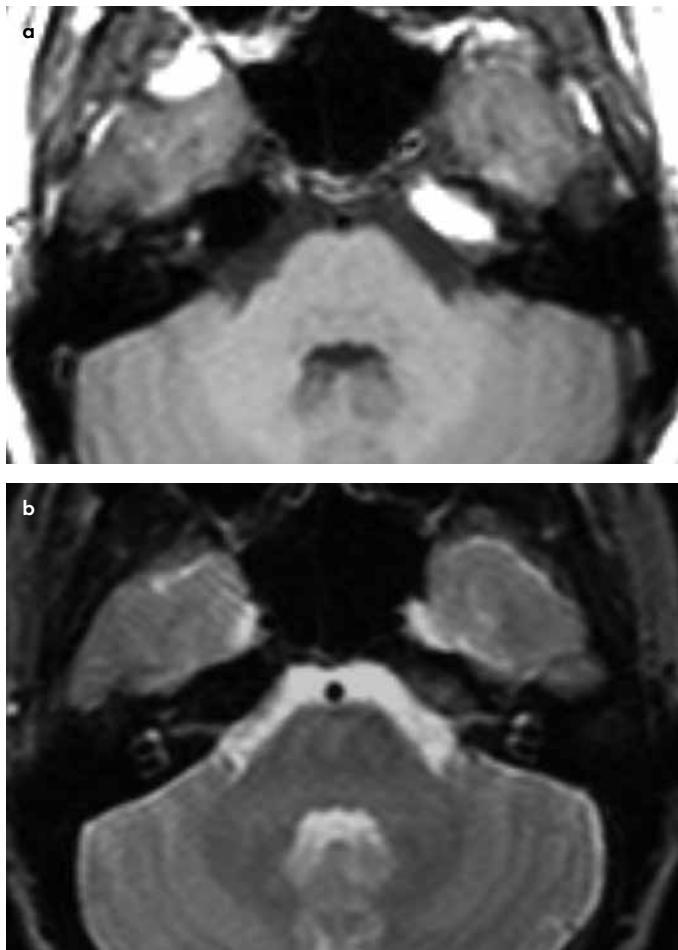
a, b. Asymmetric petrous apex. T1-weighted axial MR image shows high signal intensity of the left petrous apex suggesting cholesterol granuloma (a). T2-weighted axial MR image, however, reveals that these appearances follow the subcutaneous fat signal and consistent with non-pneumatized petrous apex (b).
